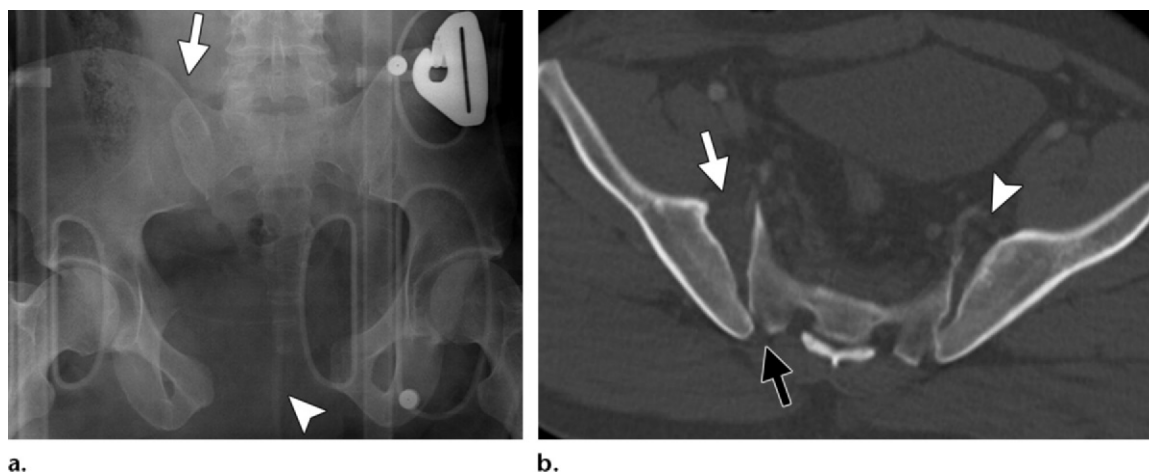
Pelvic AP radiograph (a) and axial CT image (b) obtained in a 31-year-old man show gross pubic symphysis diastasis (arrowhead in a) and significant widening of the right SI joint (white arrow). The resulting external rotation of the right hemipelvis is characteristic of AP compression. The slight posterior displacement of the right iliac side of the SI joint suggests posterior ring ligamentous disruption (black arrow in b), a finding consistent with an AP compression type 3 injury. Mild widening of the left SI joint is also seen (arrowhead in b).
